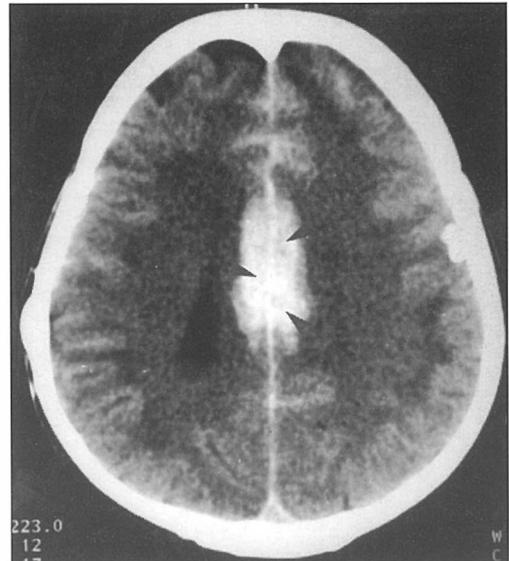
Conventional CT shows blood in subarachnoid spaces and in the interhemispheric fissure (arrows).
